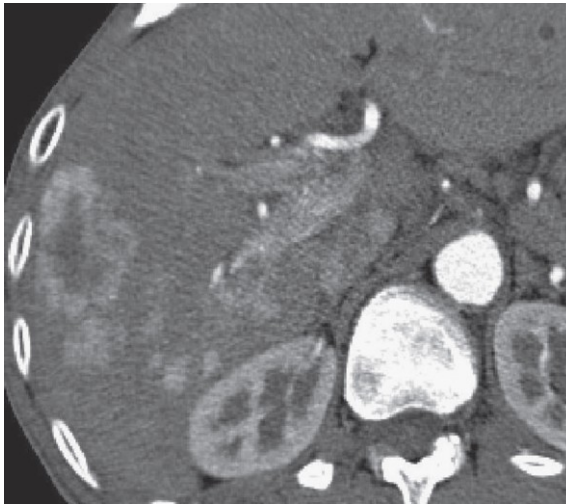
Portal vein tumour thrombus-The arterial phase of dynamic CT demonstrates multiple well-enhanced HCCs and marked enhancement showing a thread- and streak-like pattern in the proximal right portal vein.
